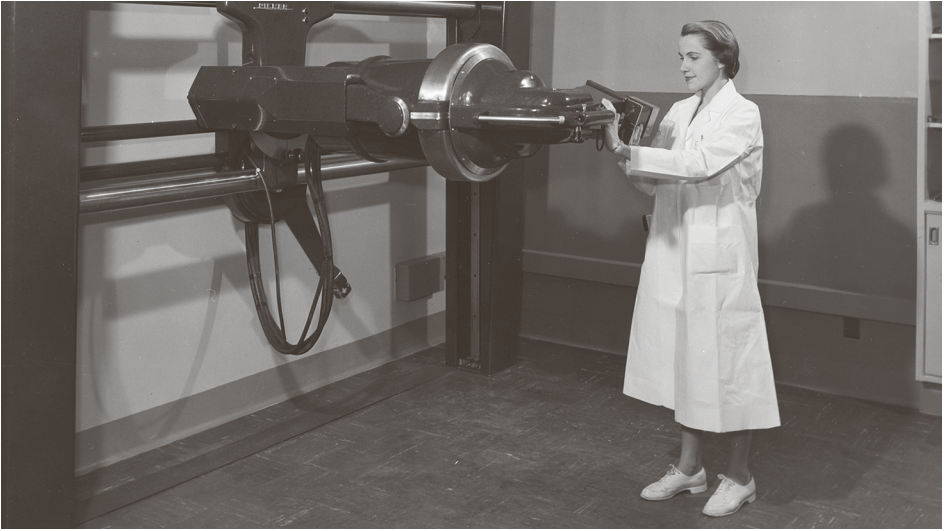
Technologist E. Pettigrew working with X-ray unit in the Ross Pavilion of the Royal Victoria Hospital, circa 1950. Photographer: Editorial Associates. Source: MUHC Archives and Special Collections, 2015-0002.04.370.*
